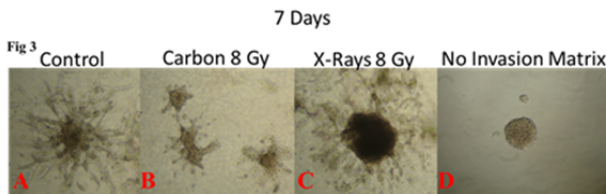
Invasion assay. Panel show sham-irradiated controls (A) and spheres derived from cells exposed to 8 Gy of carbon ions (B) or X-ray (C). Panel D displays a negative control where no matrix gel was added.
